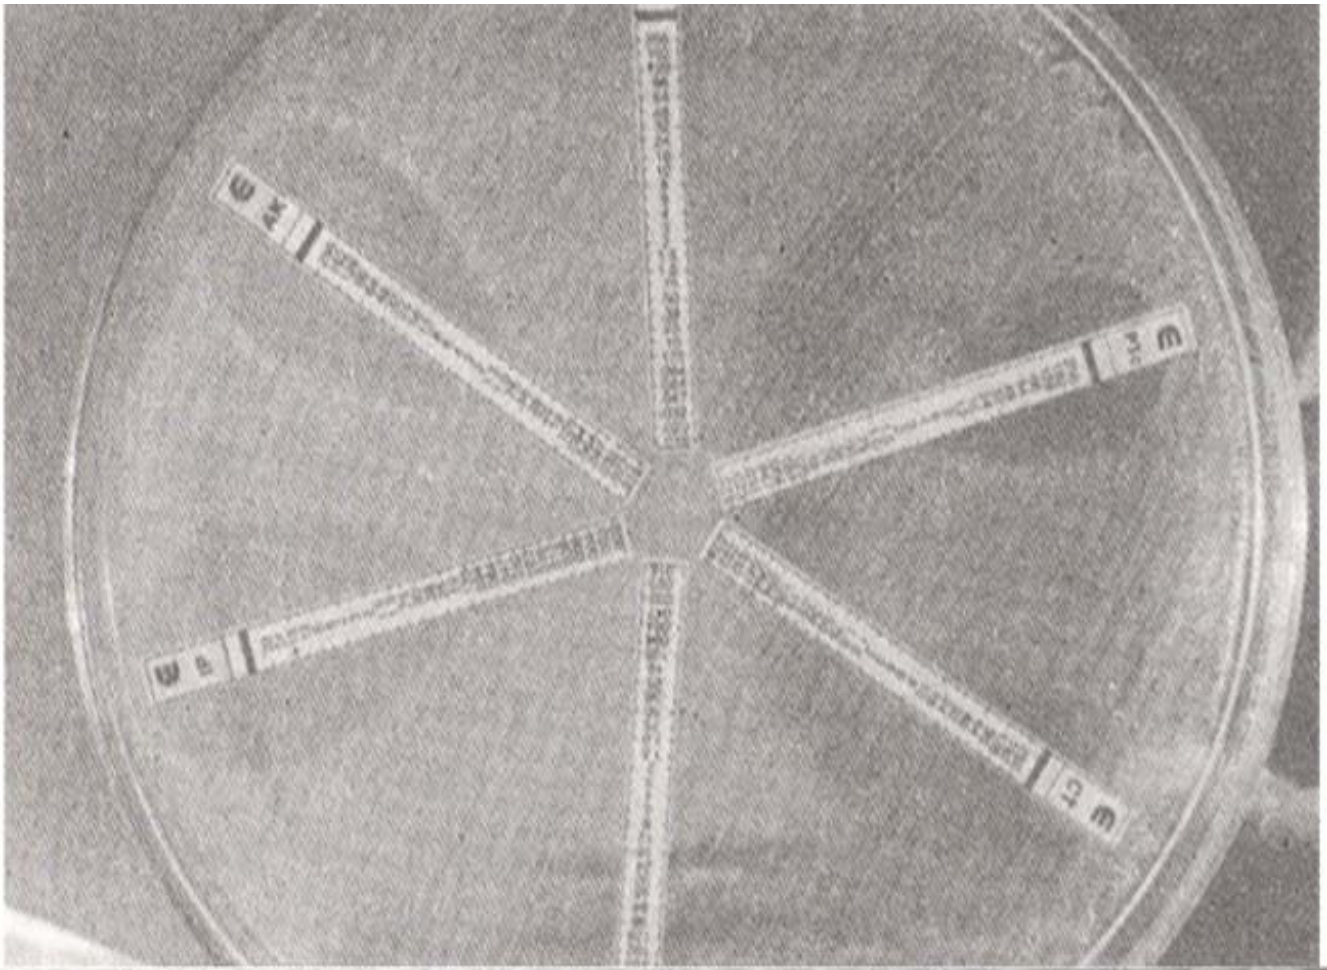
E-test demonstrated with an *Aeromonas* strain. Antibiotic abbreviations on the E-test strips and MIC interpretations are IP (imipenem 0.25 ug/ml), AK (amikacin, 2 ug/ml), CT (Cefotaxime, 32 ug/ml)
